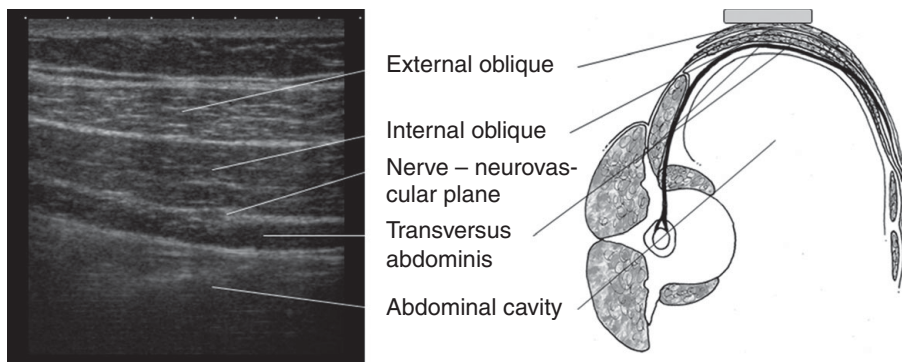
Abdominal wall anatomy. Reproduced with permission from Arthurs G, Nicholls B (eds.) 2016. *Ultrasound in Anesthesia, Critical Care, and Pain Management*. Cambridge, UK: Cambridge University Press
